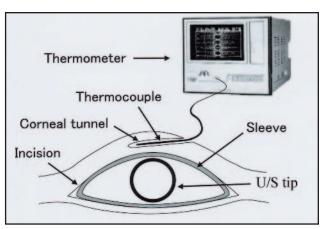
Method for measuring temperature at the incision site. The thermocouple is inserted into a tunnel created in the cornea above the incision site, and temperature at the incision site is measured with ultrasound.
